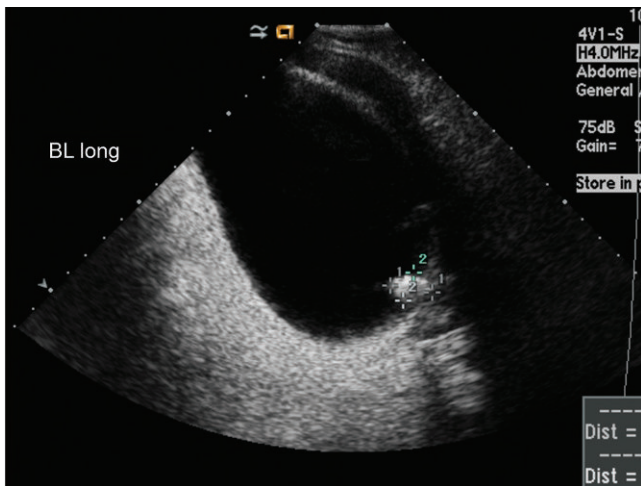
Gray scale ultrasound image demonstrates an echogenic focus (calipers) in the bladder with posterior acoustic shadowing.
